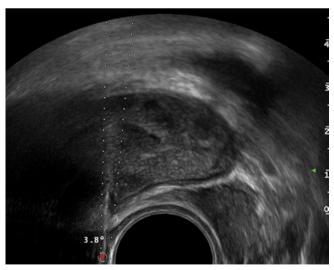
An image recorded during ultrasound-guided transrectal puncture of the lesion interpreted as the left seminal vesicle (endorectal 9 MHz probe, MyLab C, Esaote, Italy)
